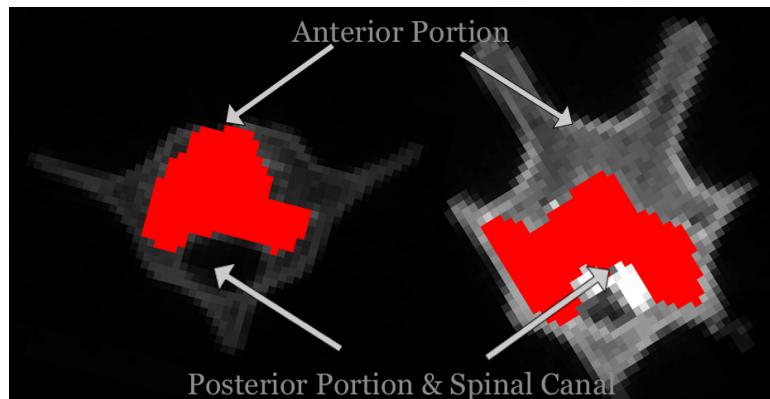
Axial μ CT slices of T2-CC2 (left) and T8-CC2 (right), with cement masked in red, showing the extend of cement fill at the point where the cement was most anterior.
